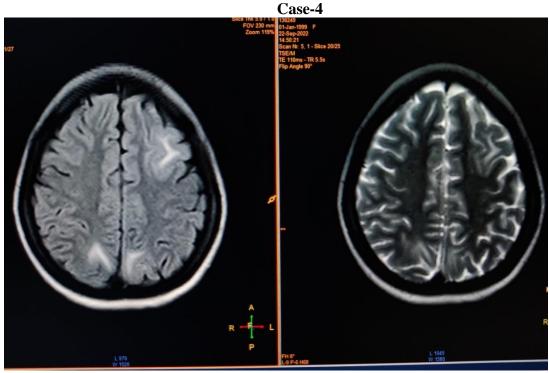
Axial FLAIR and T2-WI images showing T2/FLAIR hyperintensities noted in subcortical white matter of bilateral frontal and bilateral pariteal lobes - combination PRES.
